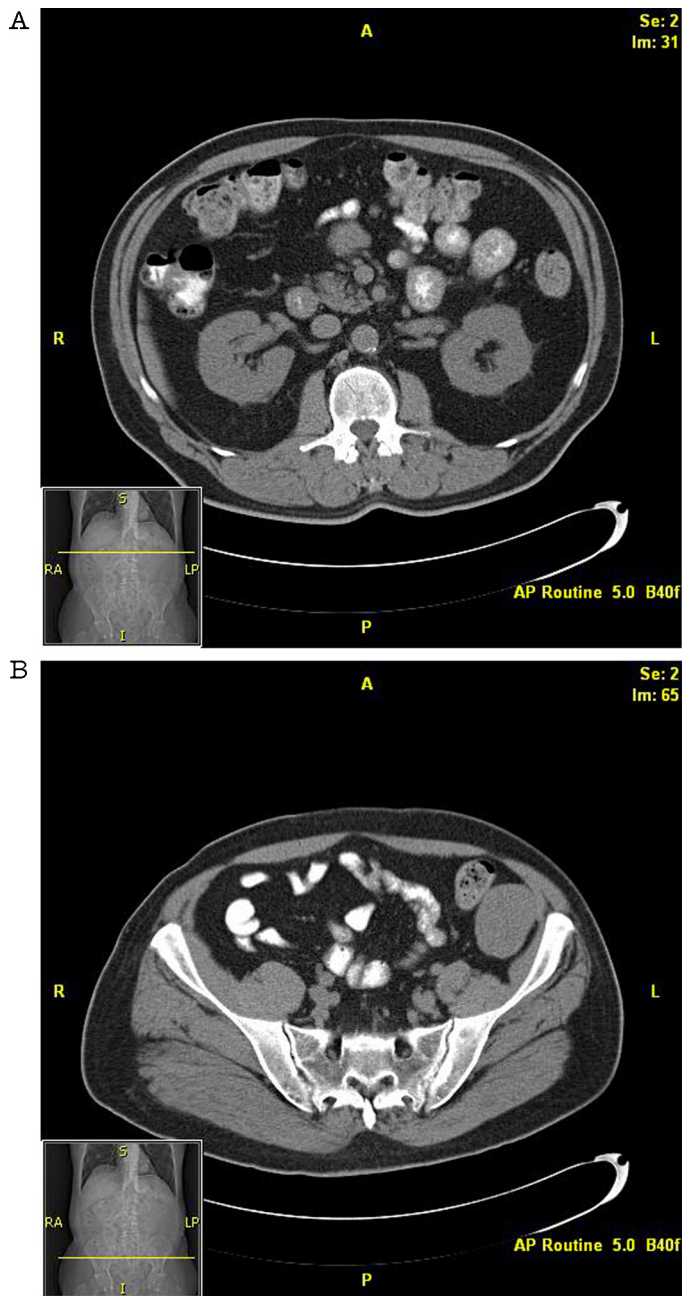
Computed tomographic scans (A and B) show metastases to small-bowel mesentery.
